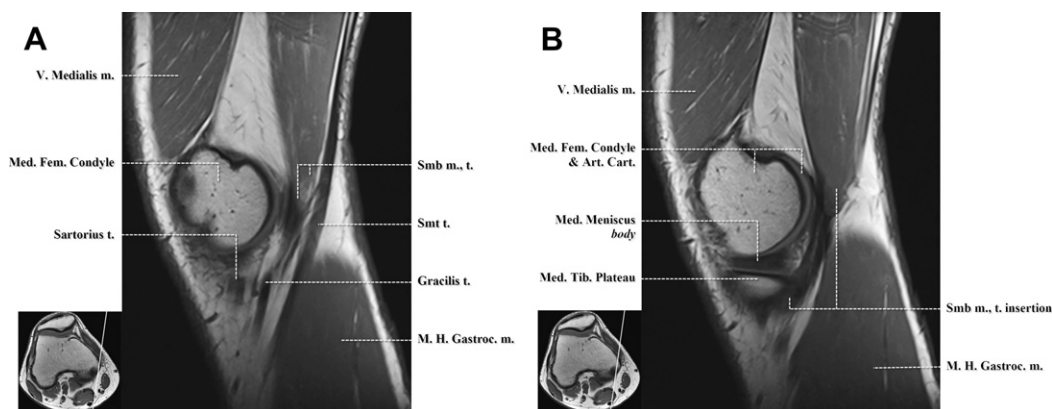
Sagittal T1-weighted images. Medial aspect of the knee. (A) m., muscle; Med. Fem., medial femoral; M.H. Gastroc., medial head gastrocnemius; Smb, semimembranosus; Smt, semitendinosus; t., tendon; V., vastus. (B) Art. Cart., articular cartilage; m., muscle; Med., medial; Med. Fem., medial femoral; Med. Tib., medial tibial; M.H. Gastroc., medial head gastrocnemius; Smb, semimembranosus; Smt, semitendinosus; t., tendon; V., vastus.
